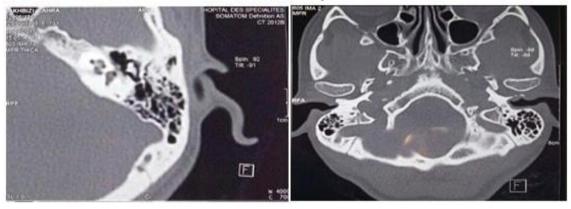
CT-Scan image of the temporal bone with axial section showing the thickening of the CAE and the lysis of the tympanic bone with the eardrum which is free.
